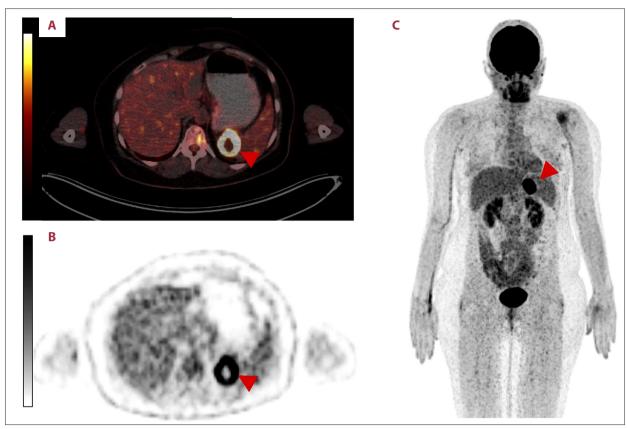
An intense circular uptake at the mediodorsal splenic pole (red arrowheads) can be seen in positron emission tomography/computed tomography (PET/CT) scan with [18F] FDG (179 MBq). (A) Exemplary transversal image of PET/CT fusion and (B) PET; (C) maximum intensity projection.
